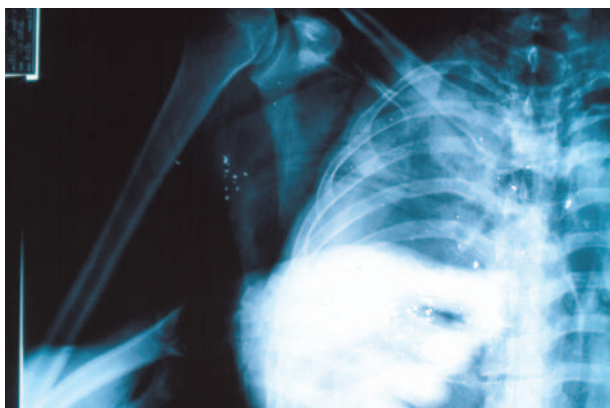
Pre post mortem radiograph showing the tell-tale “lead snow storm” trail of a high velocity projectile.
